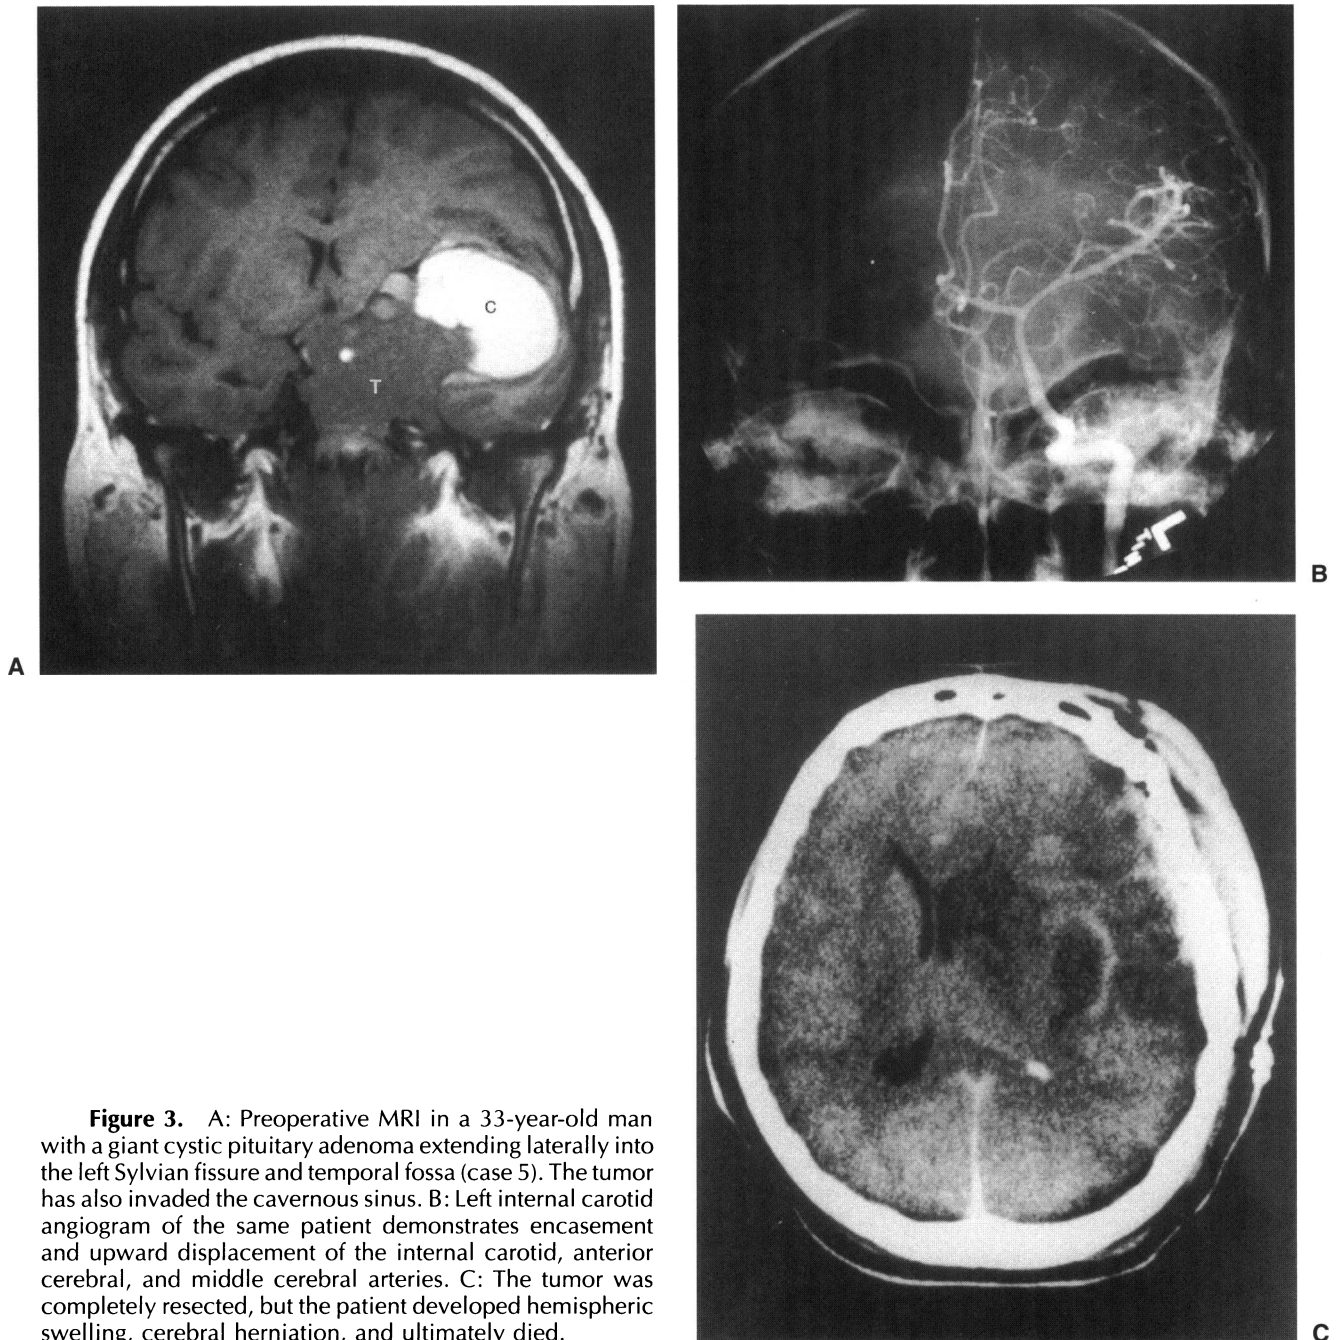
A: Preoperative MRI in a 33-year-old man with a giant cystic pituitary adenoma extending laterally into the left Sylvian fissure and temporal fossa (case 5). The tumor has also invaded the cavernous sinus. B: Left internal carotid angiogram of the same patient demonstrates encasement and upward displacement of the internal carotid, anterior cerebral, and middle cerebral arteries. C: The tumor was completely resected, but the patient developed hemispheric swelling, cerebral herniation, and ultimately died.
